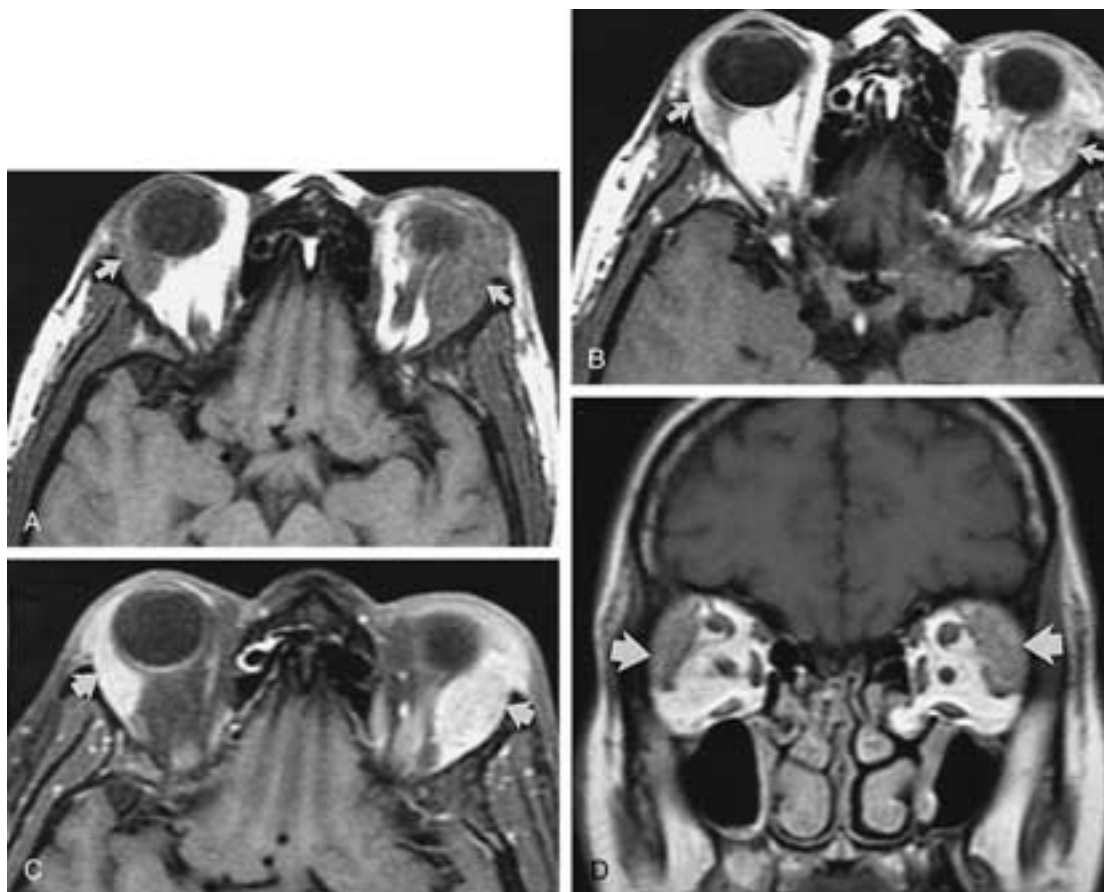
Sarcoidosis of lacrimal gland. Unenhanced, axial, T1-weighted (500/17, TR/TE) (A), enhanced, axial, T1-weighted (500/17, TR/TE) (B), enhanced, axial, fat-suppressed T1-weighted (500/17, TR/TE) (C), and enhanced, coronal, T1-weighted (600/18, TR/TE) (D) MR images show enlargement as well as increased enhancement of both lacrimal glands (*arrows*), more so on the left side. (From Mafee MF et al. Sarcoidosis of the eye, orbit, and central nervous system. Role of MRI. *Radiol Clin North Am* 1999;37:73–87.)
